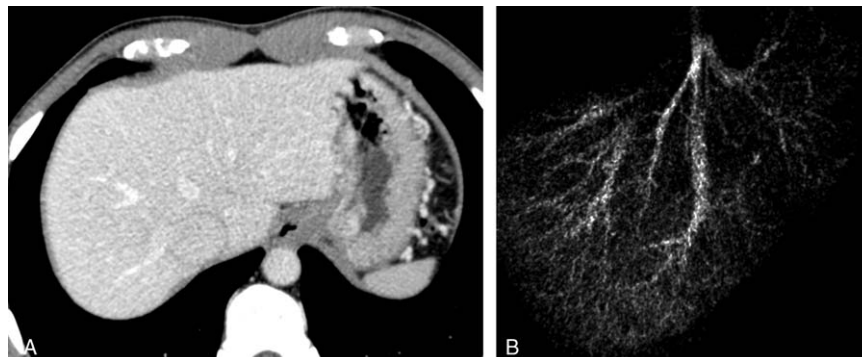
A 40-year-old female donor candidate undergoing computed tomography (CT) imaging under 120-kVp with filtered back projection (protocol A). Hepatic vein is identified but partially unclear on the axial CT (A) and volume-rendering 3D images (B). The visual score for hepatic vein was fair (score 3).
